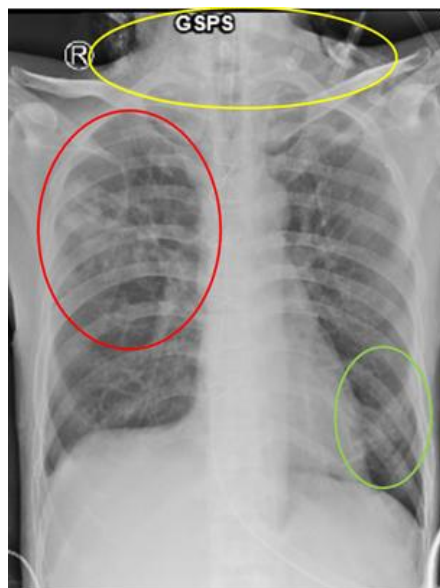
A newer patient's chest X-ray showed signs of pneumonia
